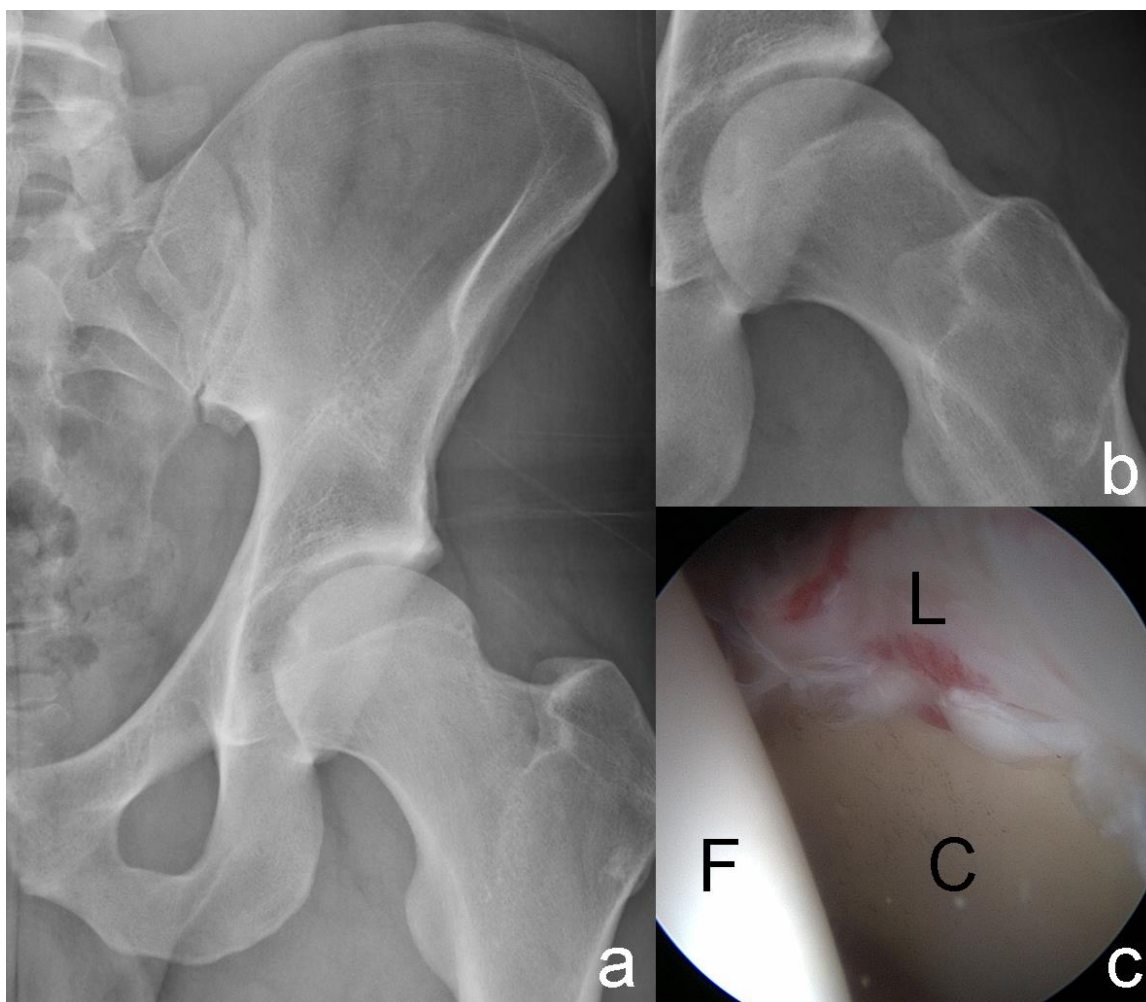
Radiographic and intraoperative imaging of the left hip of Patient 1. a) Anteroposterior radiograph showing a slightly shallow acetabulum and low-hanging AIIS. b) Frog-leg lateral radiograph highlighting decreased offset between the femoral head and neck. c) Arthroscopic view through the anterolateral portal (70 degree scope) showing a labral tear and bruising at the anterosuperior chondrolabral junction. F=Femoral head, L=Labral tear and bruising (red), C=Acetabular Cartilage.
